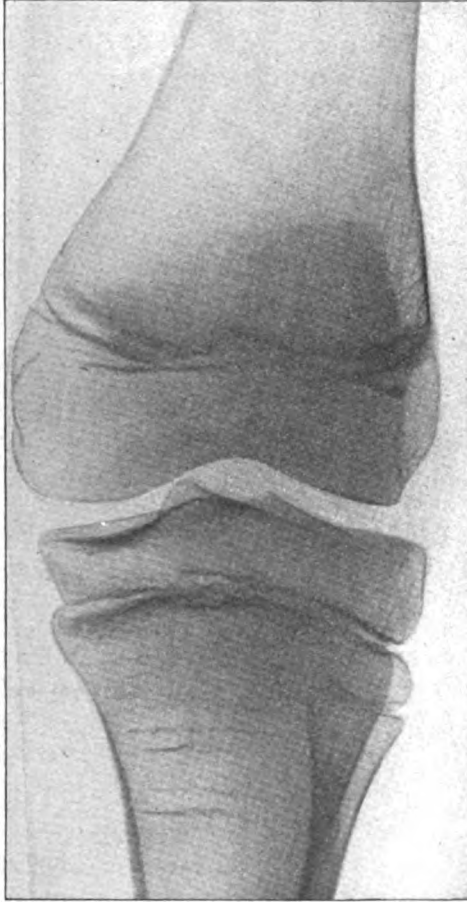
Case of W. B. X-ray of knee showing ununited epiphysis.
